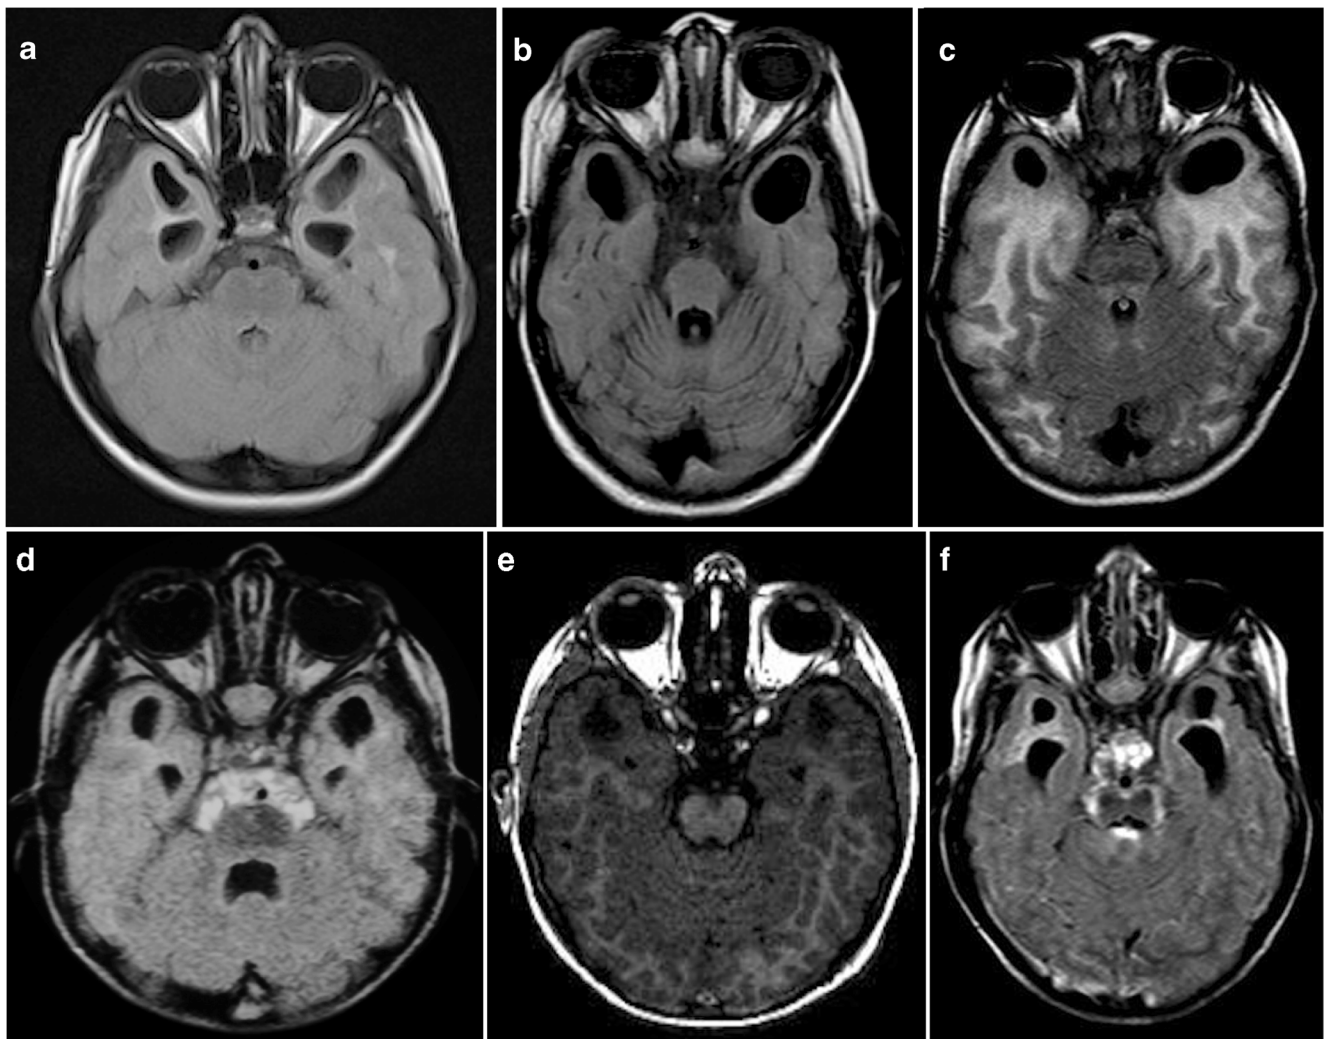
MR images demonstrate patterns of ATL; a An 8-year-old boy with congenital CMV; axial FLAIR image. b A 7-year-old girl with AGS; axial FLAIR image. c A 2-year-old boy with MLSC; axial FLAIR image.
